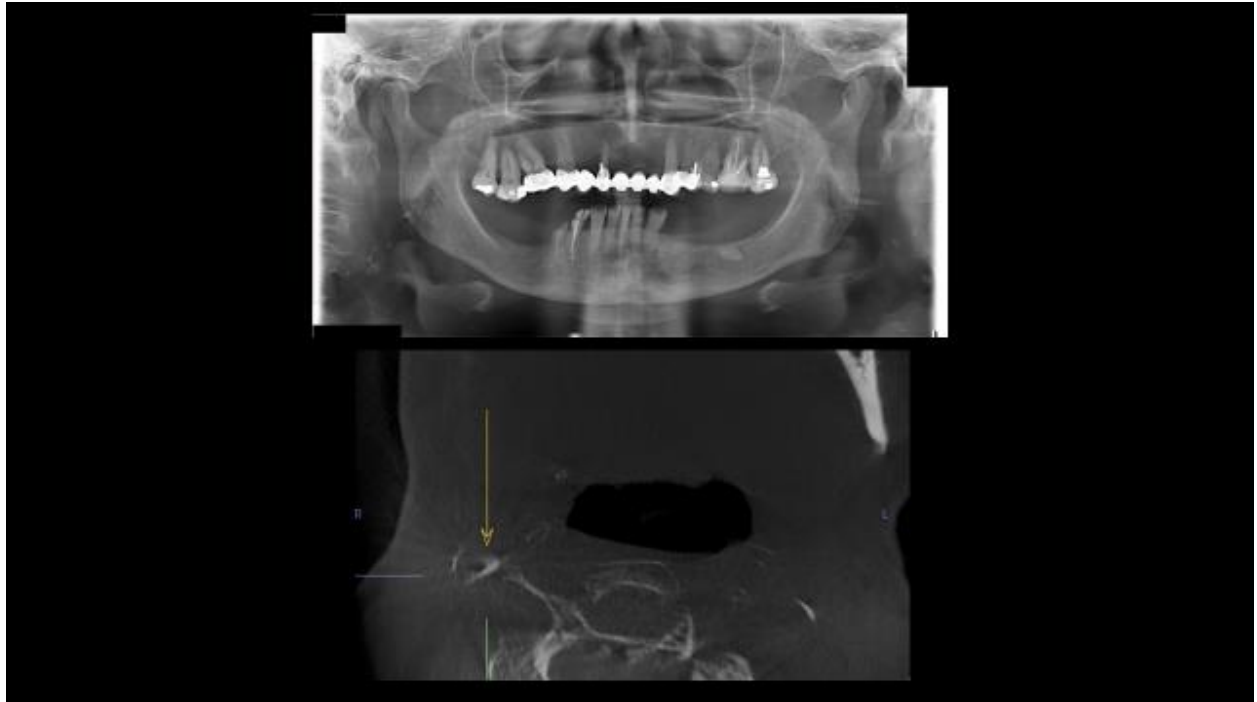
Carotid Atheroma CBCT (bottom) visible on PAN (top)
